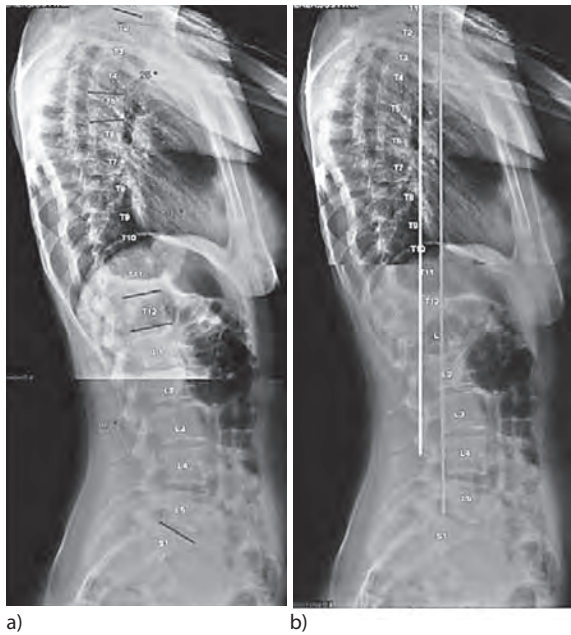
The lateral radiograph evaluation: a) the thoracic sagittal modifier (thoracic kyphosis) and lumbar lordosis, b) the sagittal balance of the spine
